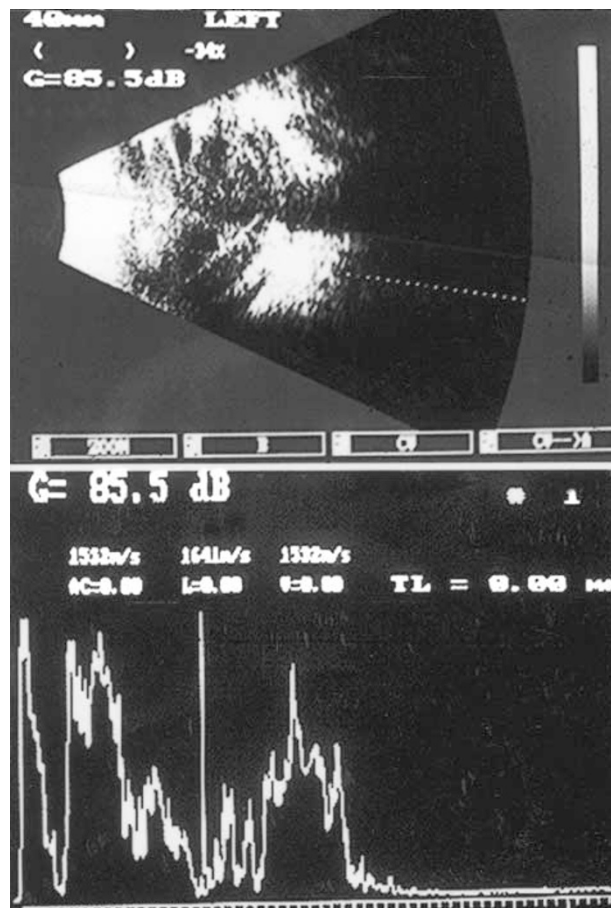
Ultrasonography B-scan (top) demonstrates an echodense intravitreal-space-occupying lesion with varying echogenicity, almost filling the entire vitreous cavity. Note the orbital shadowing. The corresponding vector A-scan (bottom) shows high internal reflectivity.
